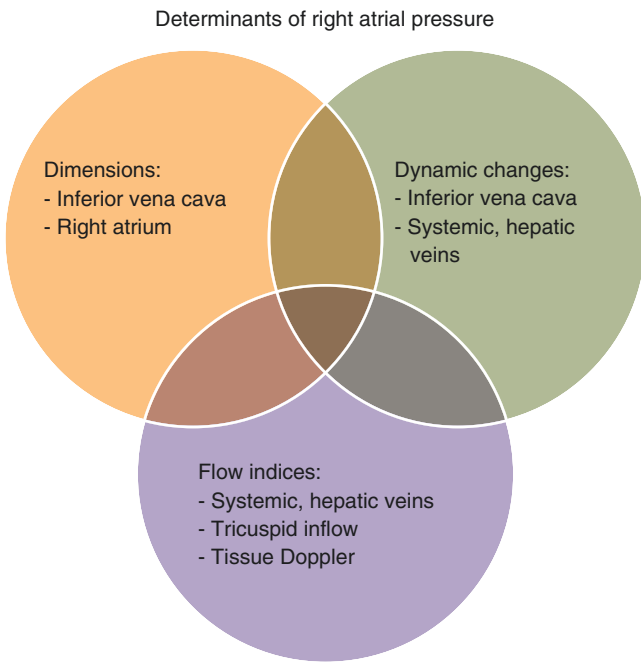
Echocardiographic determinants of right atrial pressure (RAP). The IVC diameter and collapsibility play a major role in the assessment of RAP; however, multiple factors must be taken into account to provide an accurate estimate of RAP including right atrial dimensions, Doppler and tissue Doppler assessments of the tricuspid flow, hepatic veins and tricuspid annulus. (Reproduced from Beigel et al. [1]; with permission.)
